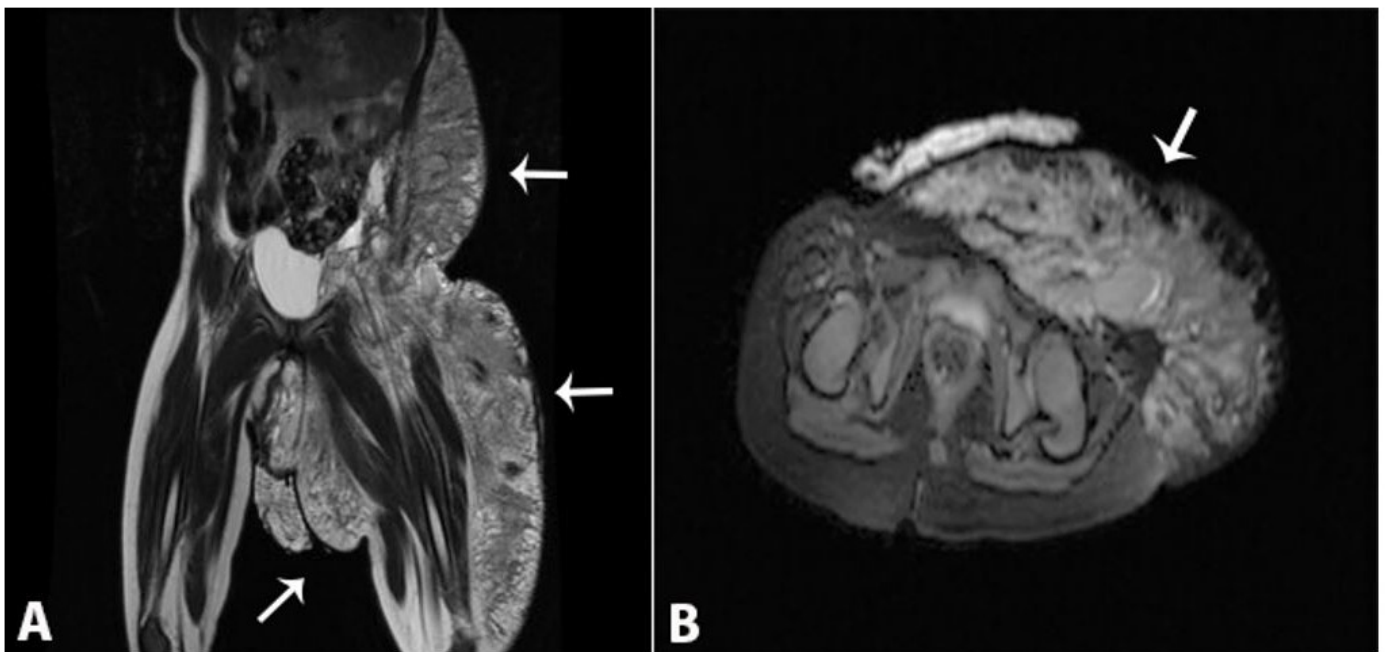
MRI of newborn at the first day of life. A - T2-weighted coronal axis showing the complex cystic/solid pelvic mass (arrows); B - T1-weighted fat saturated axial MRI showing the lymphatic malformation (arrow).
